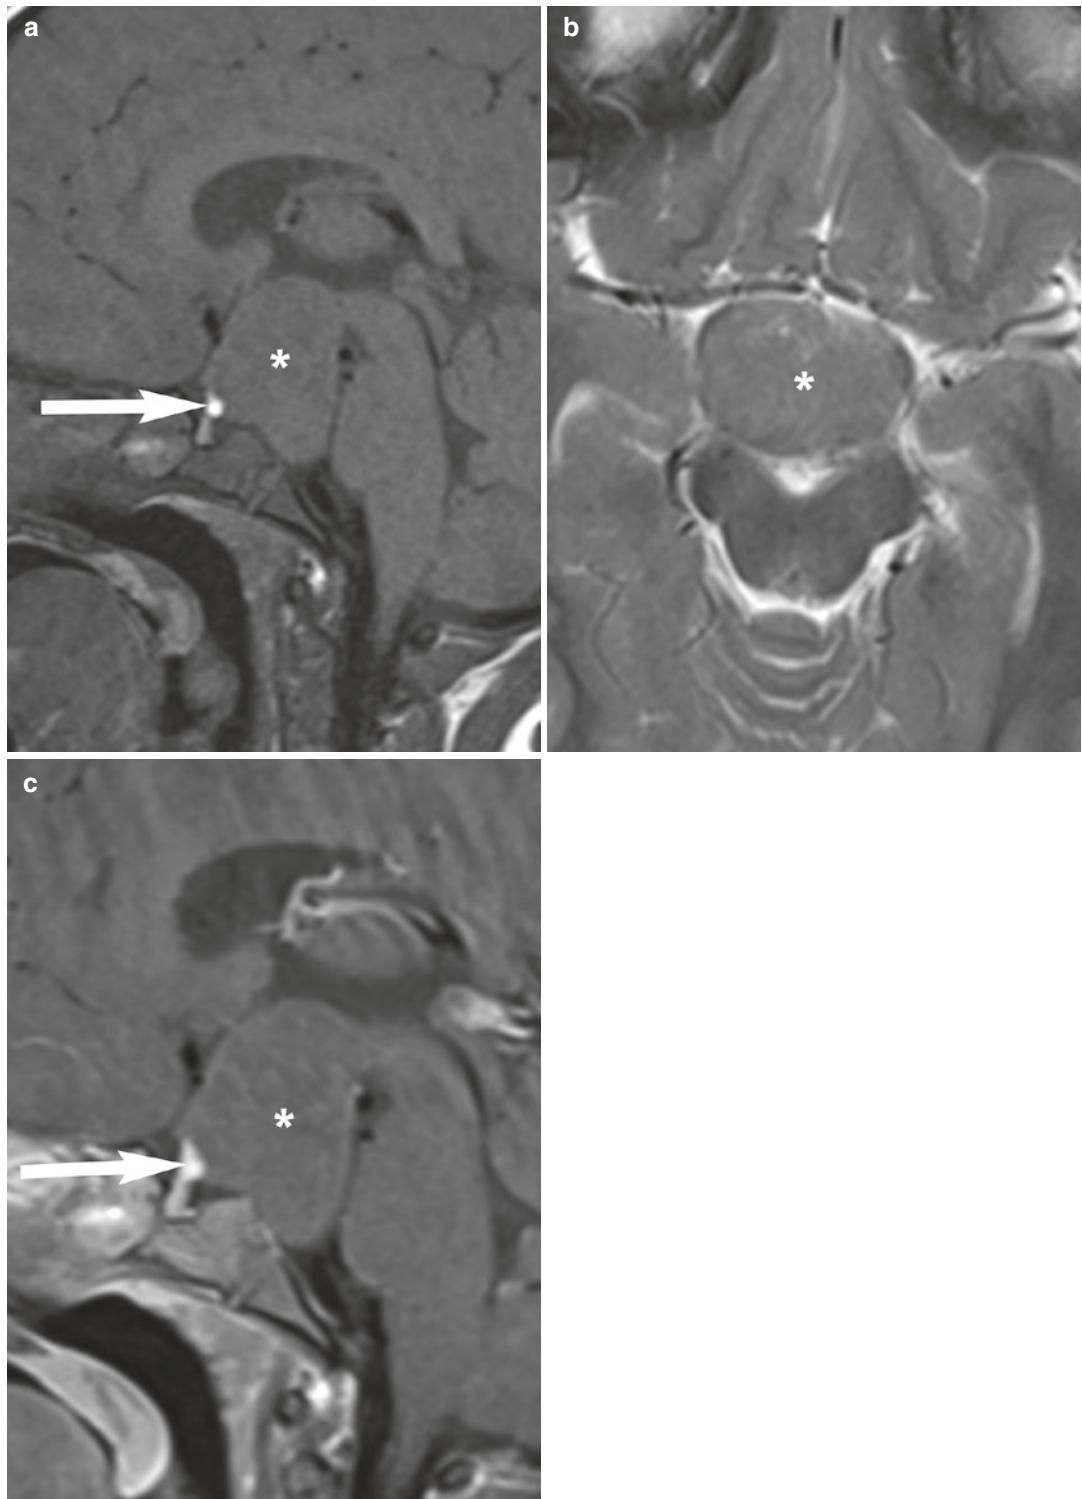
Hypothalamic hamartoma. A 14-month-old male with uncontrollable seizures. Sagittal unenhanced T1-weighted (a) and axial unenhanced T2-weighted (b) show lobulated mass (*) in the hypothalamus which is
